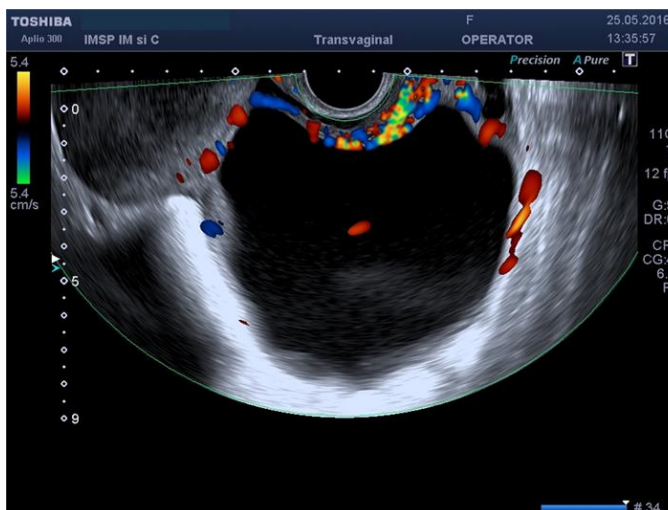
Transvaginal ultrasonography with Doppler velocimetry: SCA of the right ovary 111x96 mm
